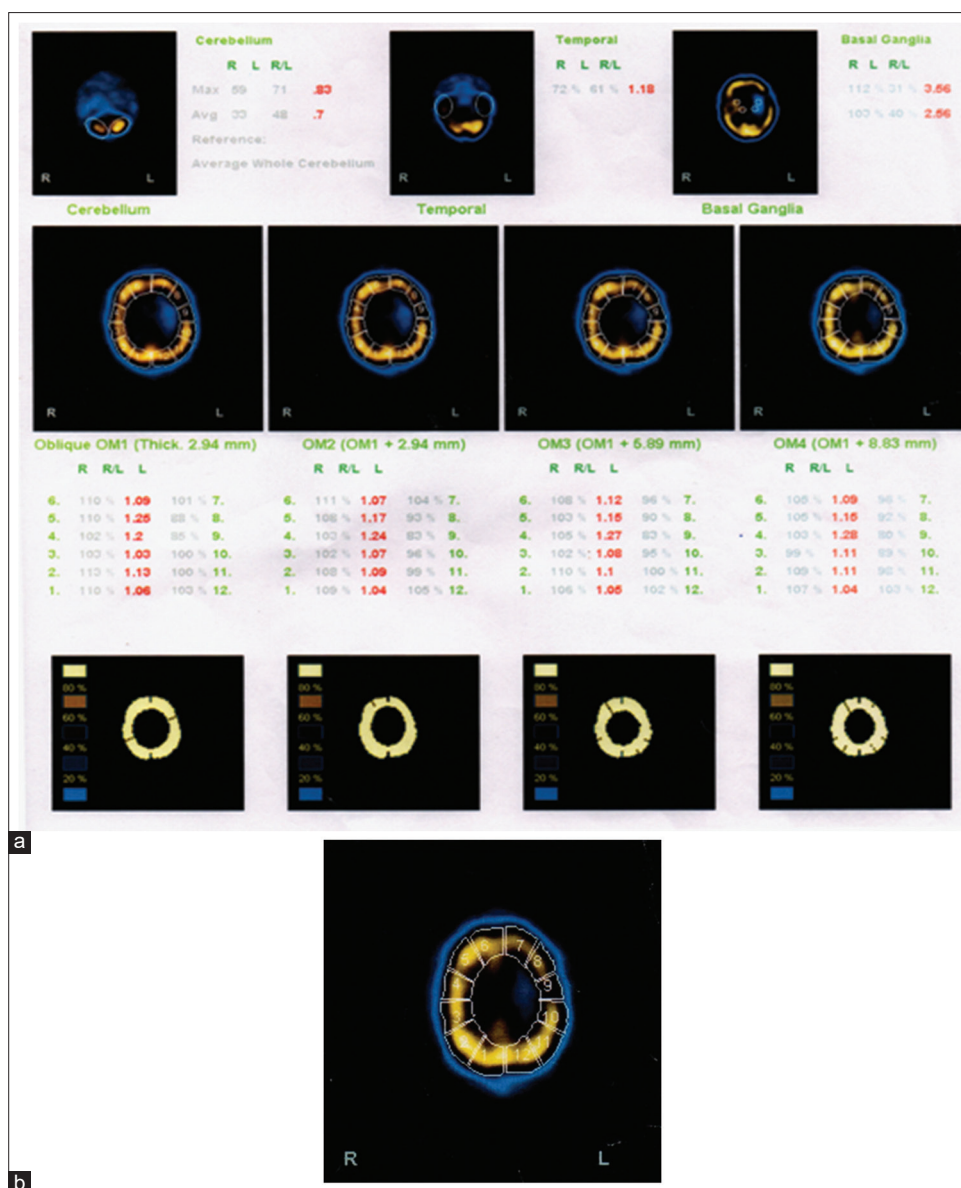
(a) explains the SPECT study report of a 65 yrs old lady. She was newly detected hypertensive and had developed left putaminal bleed with NIHSS score of 19, intra cerebral hemorrhage score of 2, intra cerebral hemorrhage volume (60 cc) having Grade 3 perilesional edema on computed tomography scan brain and perfusion deficit of 23%. Single-photon emission computed tomography study image zoomed of the same patient can be seen in. (b) where segment 9 when compared to segment 4 shows a difference in radiotracer uptake of 23%
